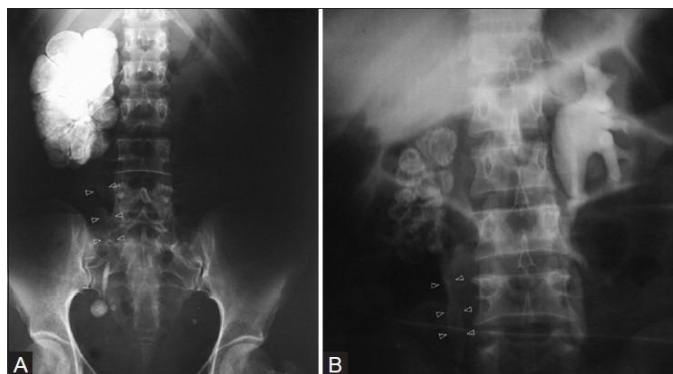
Plain radiograph revealing classic lobar pattern of calcification, which is pathognomonic of end-stage renal tuberculosis. Ureteral calcification is also noted, which is fainter in upper parts (arrowheads), Fig 1B: intravenous urogram revealing the 'classic' lobar pattern of calcification in a non-functioning right kidney.
